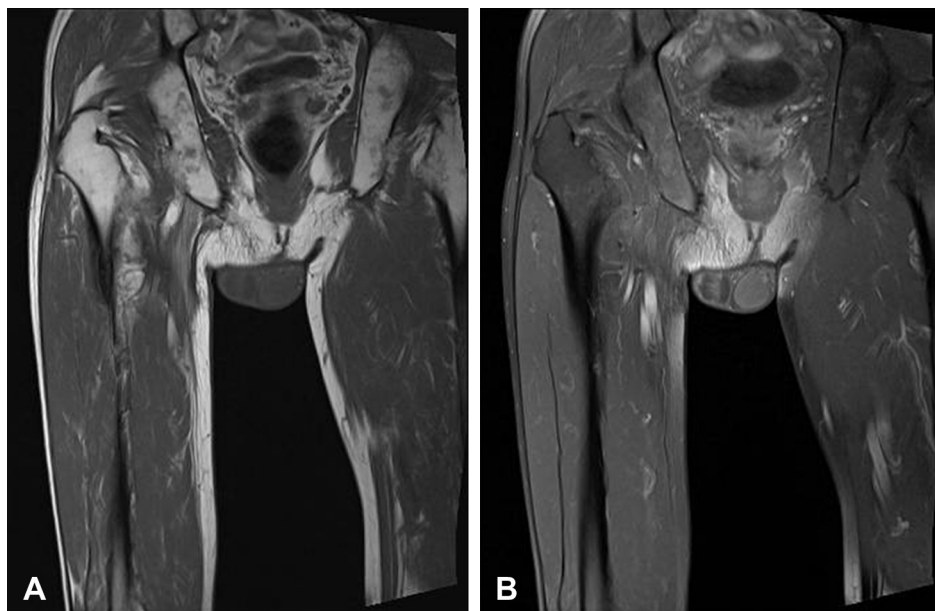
Magnetic resonance imaging at the 2-year postoperative follow-up. (A) Coronal T1-weighted imaging, and (B) fat-suppressed Gd-enhanced T1-weighted imaging revealed mild muscle atrophy at the medial aspect of the right thigh without evidence of local tumor recurrence.
